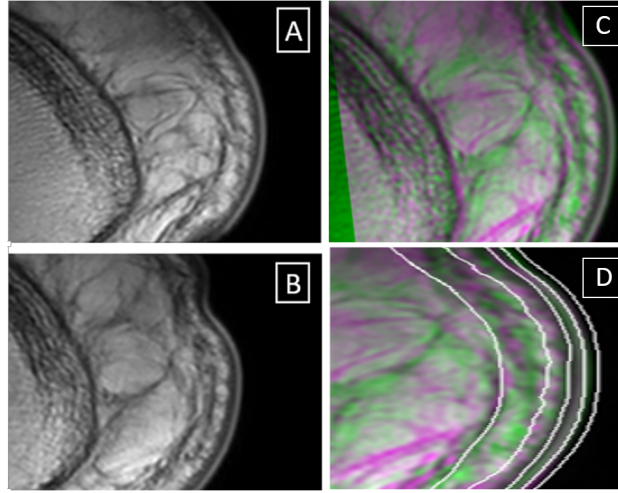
Registration. A, Second echo of the multi spin echo calculation T2-weighted sequence before moisturization. B, Second echo of the multi spin echo calculation T2-weighted sequence after moisturization. C, Registration of images A (fixed) and B (moving). D, highlighting the segmentation of B on image C.
